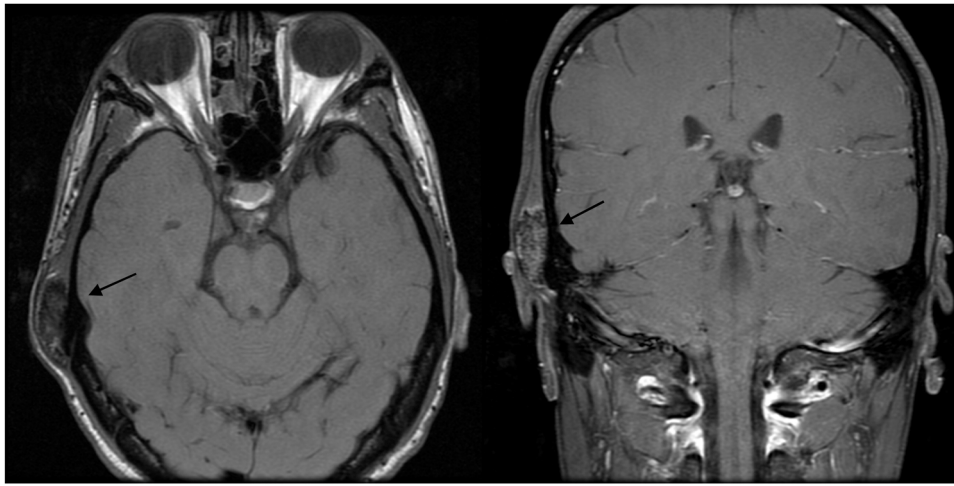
MRI skull: parosteal osteosarcoma of skull: Densely calcified mass (arrows) measuring $3.6 \times 1.5 \times 3.0$ cm involving the inferior aspect of the squamous portion of the right temporal bone that is immediately superior to the petrous portion.
